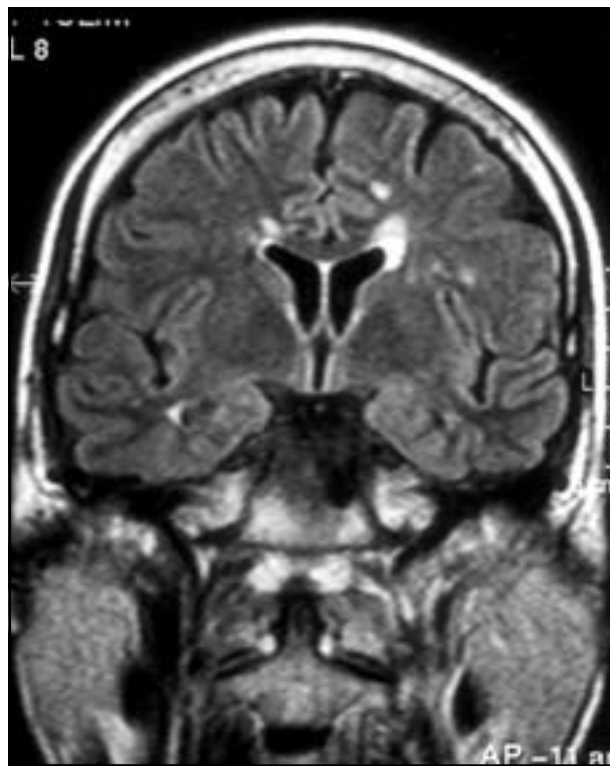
A coronal MR image exhibits multiple lesions in the white matter, suggestive of multiple sclerosis.
